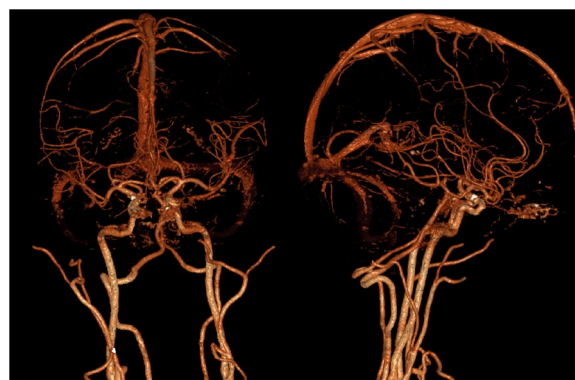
Head and neck computed tomography angiography of patient 1—no lesions in the main vessels
